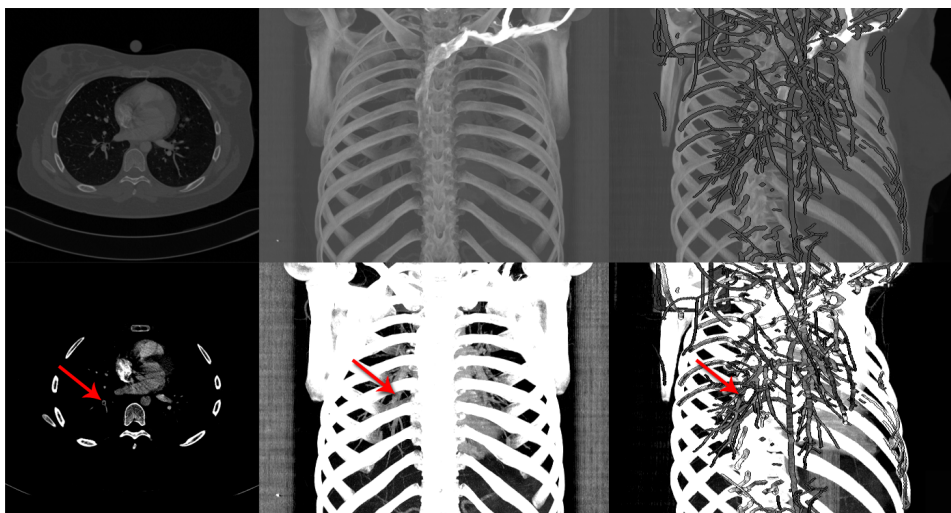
Resulting images of a pulmonary embolism detection of a human lung CTA dataset. The red arrows indicate the position of the embolism. The top row shows the data with no contrast enhancement, hence it is hardly possible to see the embolism, whereas in the bottom row the contrast is significantly enhanced in order to make the embolism visible. The first column shows the transversal slice, the second presents the frontal view and the third column renders the vessels using CR with MIP as context, viewed from a specified angle along the z-axis. (Images created using the AngioVis Toolbox)*
